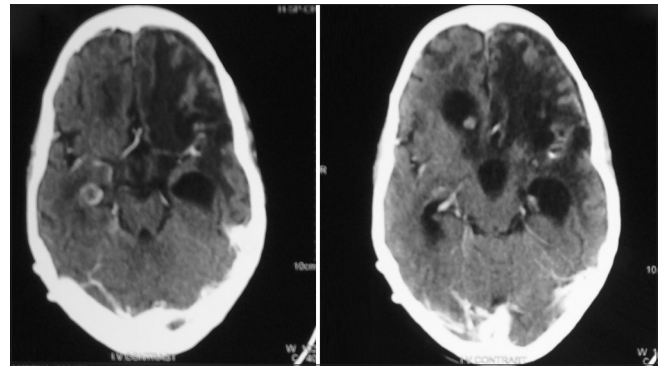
Contrast CT scan head showing an intraventricular cyst in right frontal horn and another periventricular hydatid cyst in right temporal horn along with hydrocephalus
